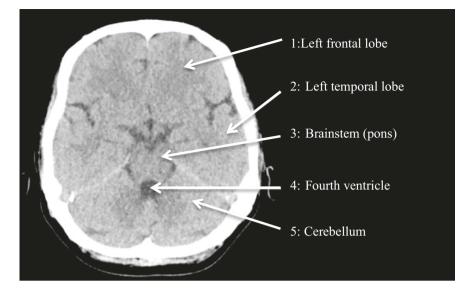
Axial non-contrast CT brain
